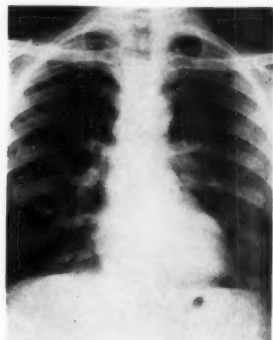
Radiograph showing "snowstorm" silicosis in a sandblaster.
